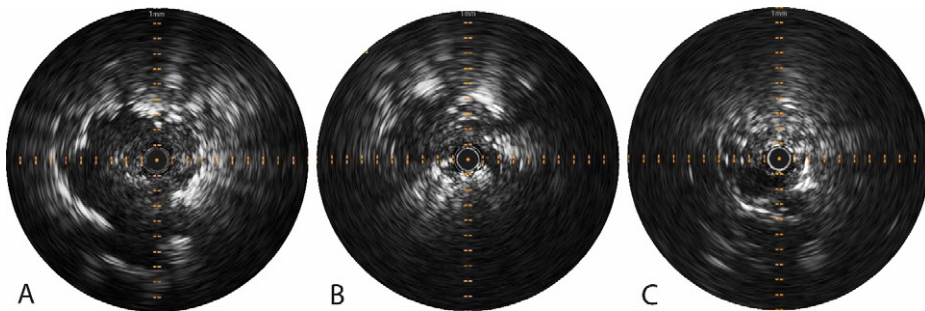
Visualization of a solid lesion (A), part-solid lesion (B), and GGO (C) on radial US imaging via the Pioneer Plus catheter after having completed diagnostic navigation bronchoscopy, pre-injection. (A) The solid lesion is clearly visualized. Beyond the lesion, some intra-parenchymal bleeding following previous sampling altered the echogenicity of the lung parenchyma. (B) The part-solid lesion is visualized, along with the GGO component that can be predominantly seen from 9 to 12 o'clock. Some hyper-echoic speckle is seen at the 4 to 7 o'clock position, following minor bleeding after biopsy. (C) The image of the GGO not only shows a mixed blizzard sign (as mentioned by Park et al. [81]) but also a clear (pulsating) vessel from the 6 to 9 o'clock position. The vessel should be out of the vicinity of the needle at the 12 o'clock position and should therefore stay in the 3 to 9 o'clock position during injection. GGO, ground-glass opacity; US, ultrasound.
